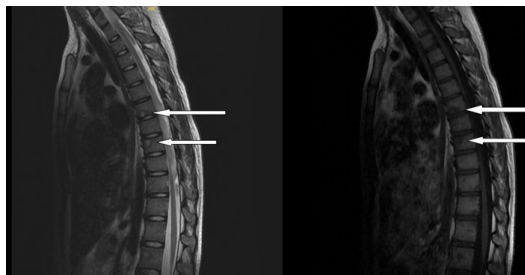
MRI of the thoracic spine
